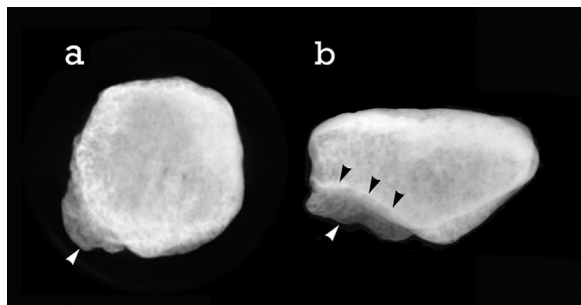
X-ray images of the ATD6-56 left patella; anterior (a) and inferior (b) views; the white arrows point to the osteophyte and the black arrows point to the boundary between the patellar bone and the bone overgrowth (osteophyte).
